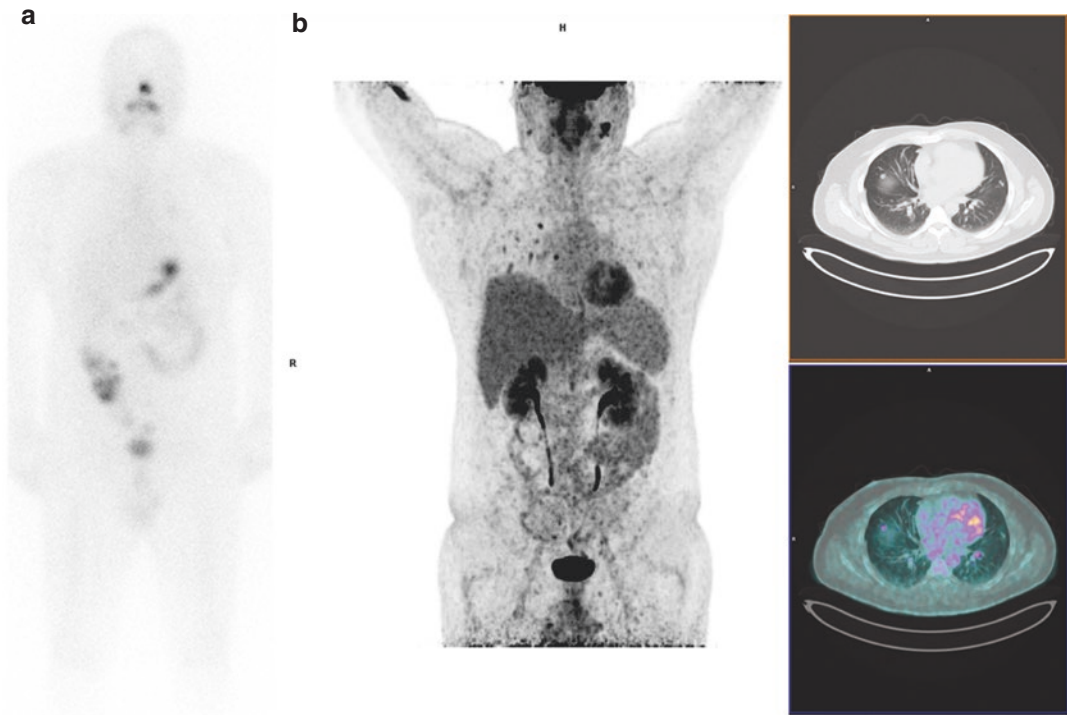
Radiiodine anterior whole-body scan (A) and FDG PET/CT scan (B) in a 45-year-old male patient submitted to total thyroidectomy and radioiodine therapy for
